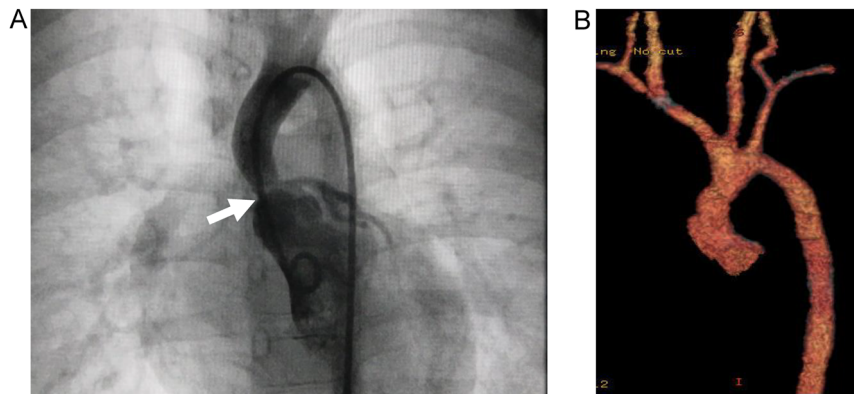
Radiographic images
